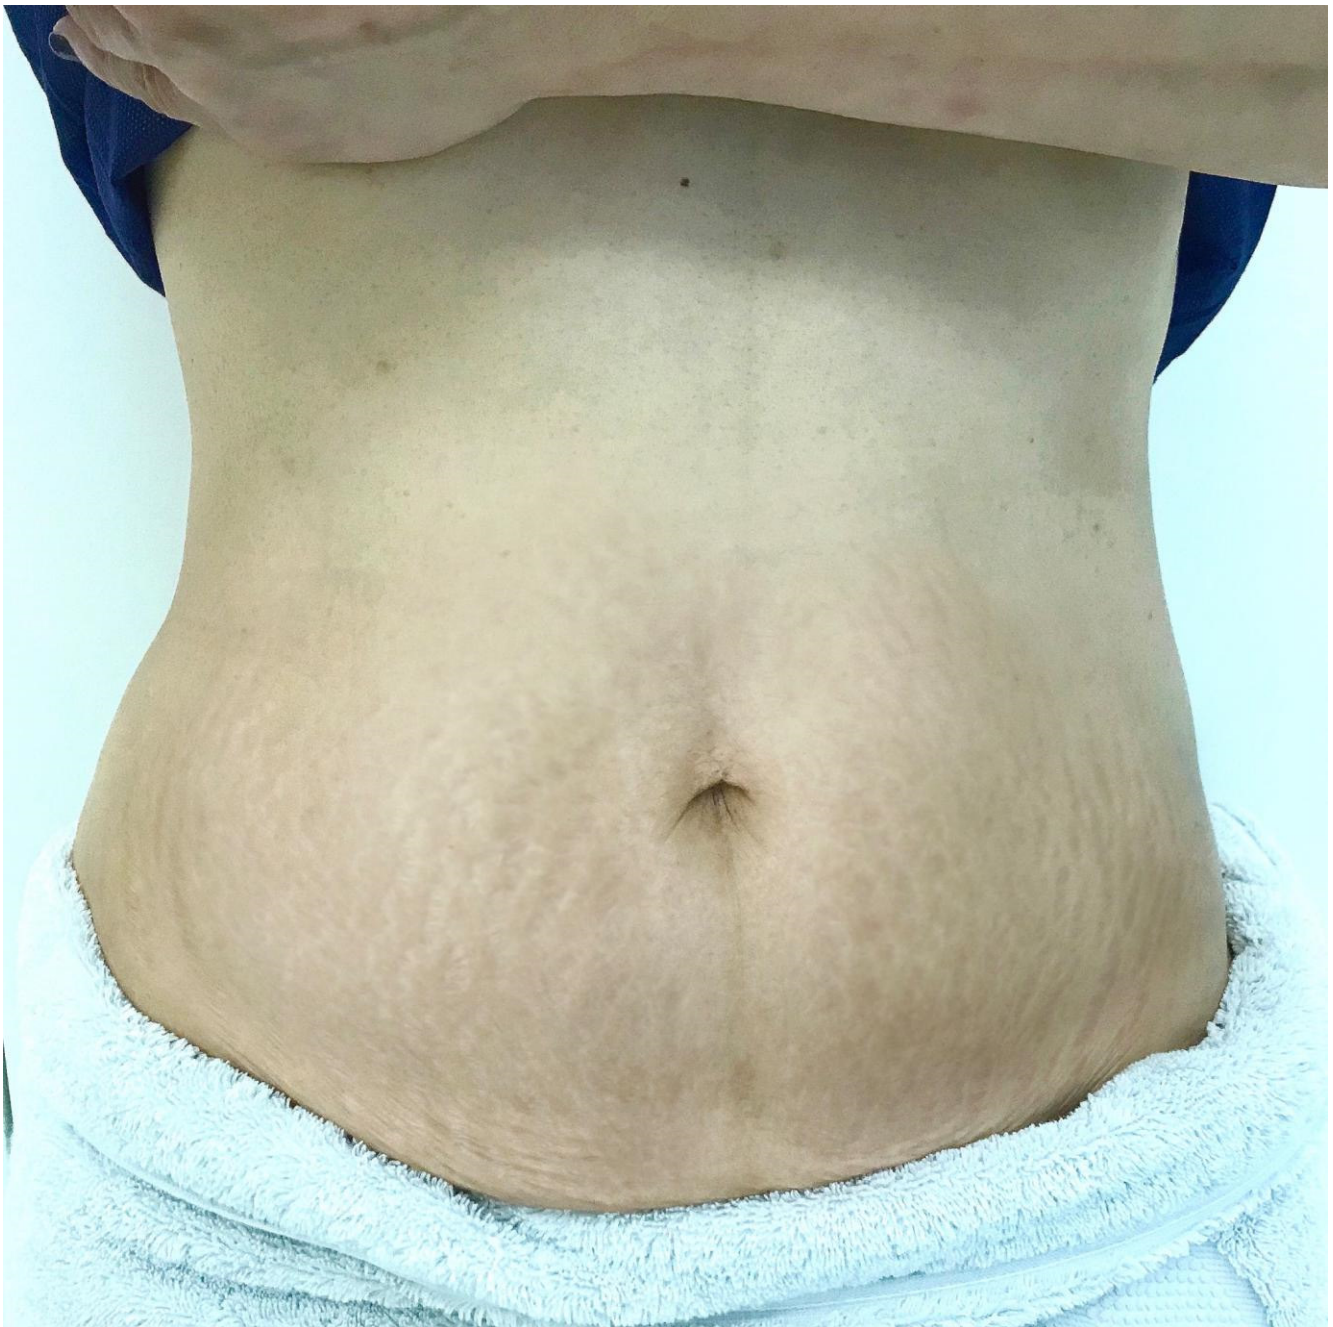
Case 2, Microfocused Ultrasound 810 shots only (4 weeks after treatment).
